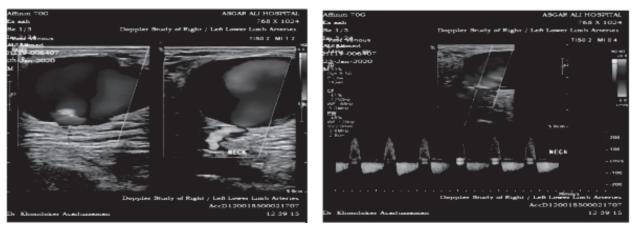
Doppler ultrasound showing the pseudoaneurysm with neck connecting the common femoral artery.
